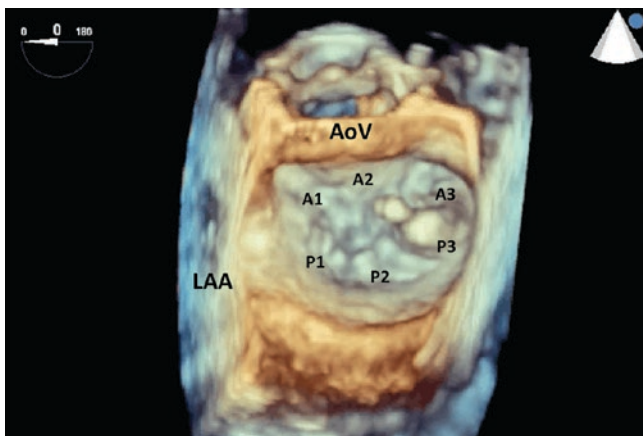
3D echocardiogram demonstrating the mitral valve in the “surgeon’s view” with the aortic valve (AoV) at the 12 o’clock location and left atrial appendage (LAA) on the lateral aspect. One can now visualize all six scallops of the mitral valve. Note that the P3 scallop prolapses and is flail
